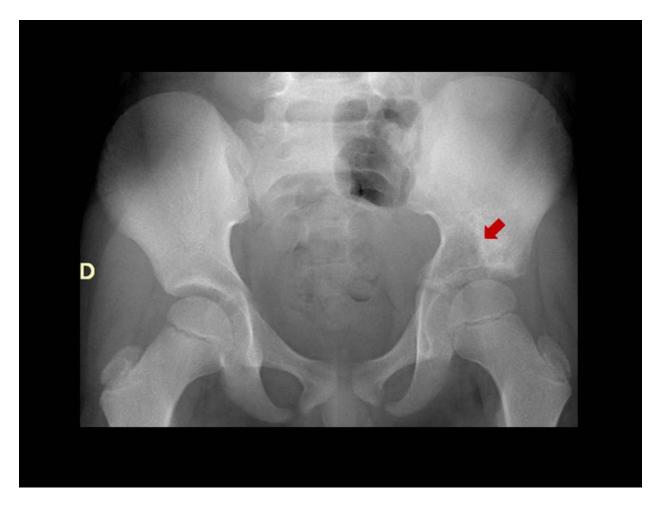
Ewing sarcoma. Anterior-posterior radiography of pelvis shows ill-defined lytic lesion in the iliac bone (arrow).
